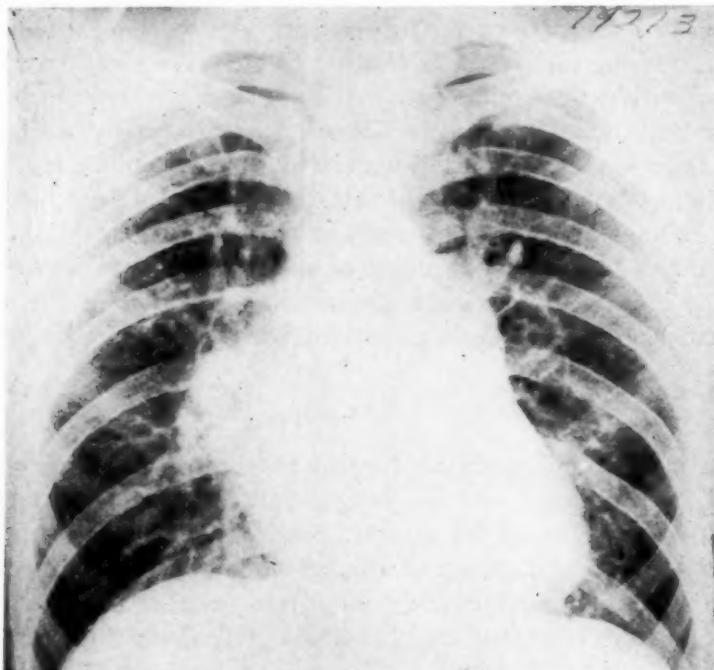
Case reported in the Addendum. Posteroanterior roentgenogram of the chest, showing cardiac enlargement, predominantly right ventricular, and prominence of the pulmonary arteries.
